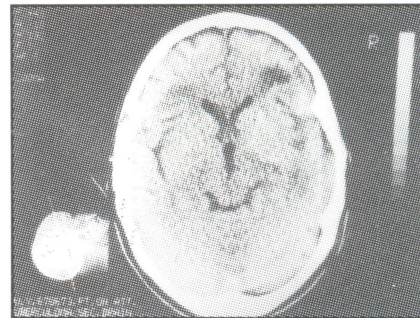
CT scan head showing small skull normal ventricular system and widening of sulci.
